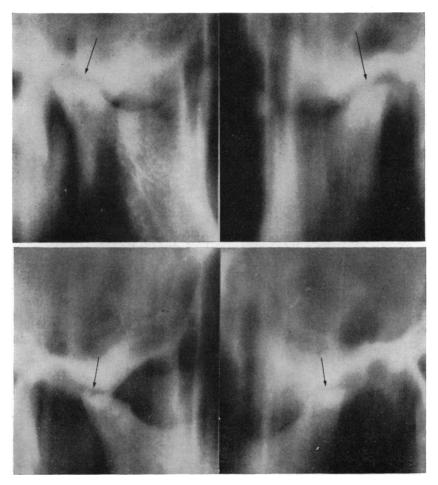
Tomograms of a girl of 24 showing destruction of the articular surfaces of the condyle and erosion of the eminentia 3 years after the first episode of dislocation when the X-rays were normal.
